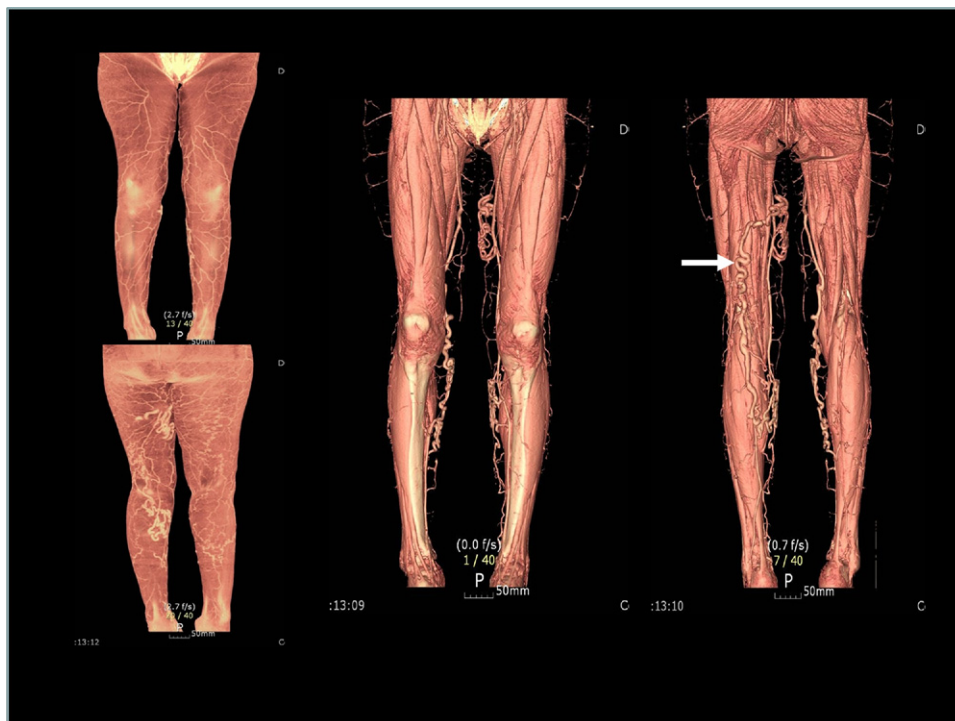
CT venography images as a navigator for surgery. The distribution of the varicosities could be seen in skin level and subcutaneous level. Duplex ultrasound exam confirmed the reflux in both GSV and left anterior accessory GSV extending to the posterior thigh (*arrow*).
